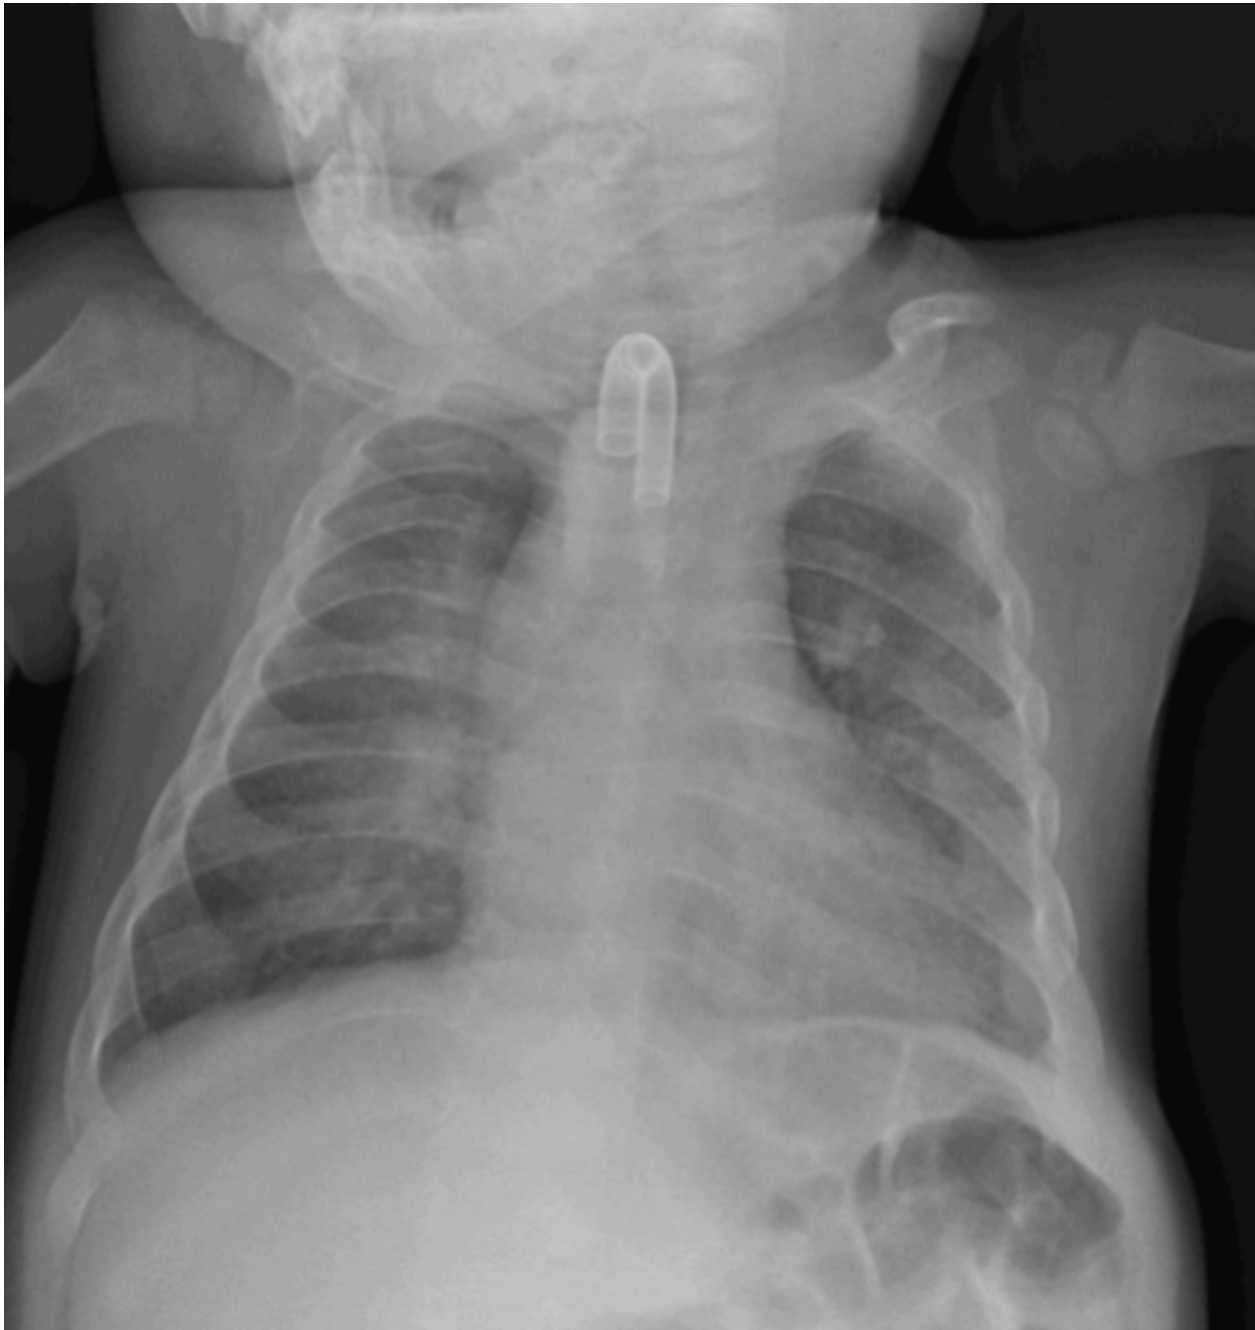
Radiograph of treated hypophosphatasia. Individual from Figure 2A after 12 months of asfotase alfa enzyme replacement therapy. Note tracheostomy tube, placed for laryngomalacia and bronchomalacia, features of the treated disease. Rachitic rib and metaphyseal changes have resolved. The two epiphyseal growth centers at the proximal humeri are normal.
